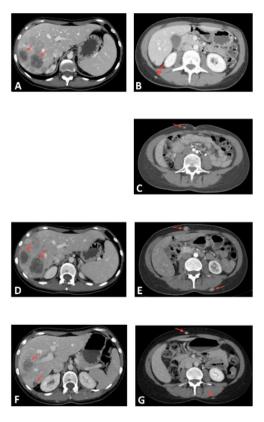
CT scan analysis, liver and cutaneous metastases are shown (red arrows) at diagnoses (A-B), during second line chemotherapy (C), during third line chemotherapy (D-E), during the last chemotherapy treatment (F-G).
